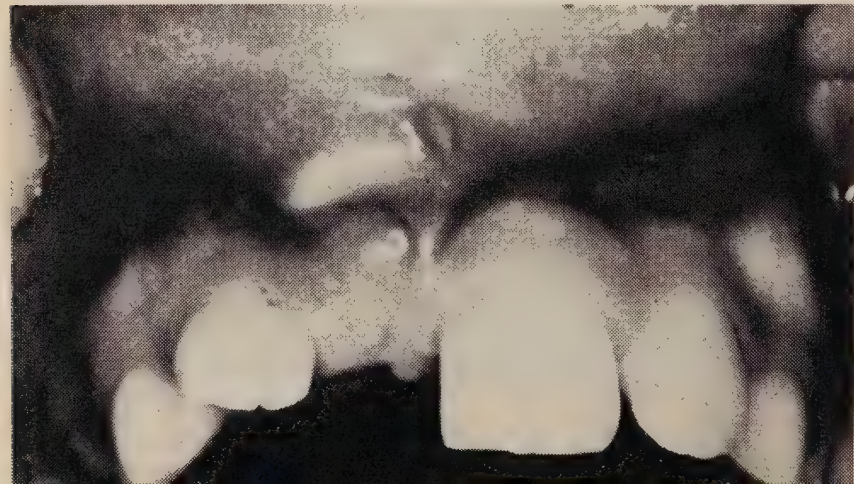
Left: unerupted upper right permanent central incisor lying high in the alveolar process. The tooth is trying to erupt through the mucous membrane of the upper lip. Right: radiograph shows the crown of this tooth almost at a right angle to the root. The deciduous predecessor was intruded during infancy and subsequently had to be extracted.
